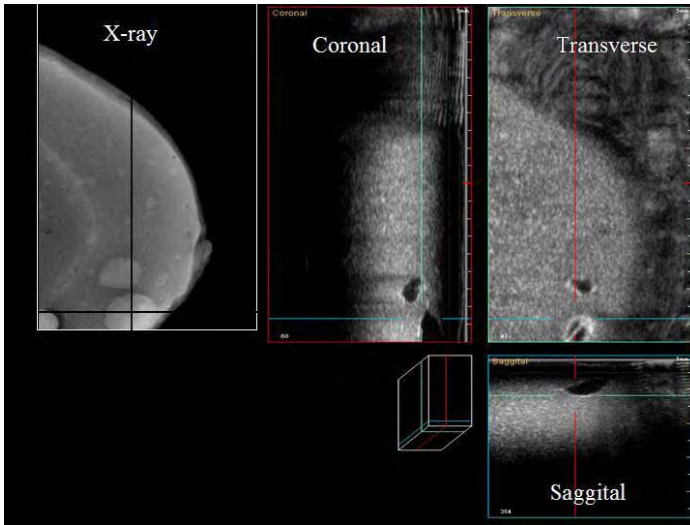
FFDMUS co-registered images: X-ray projection and three orthogonal ultrasound slices.
